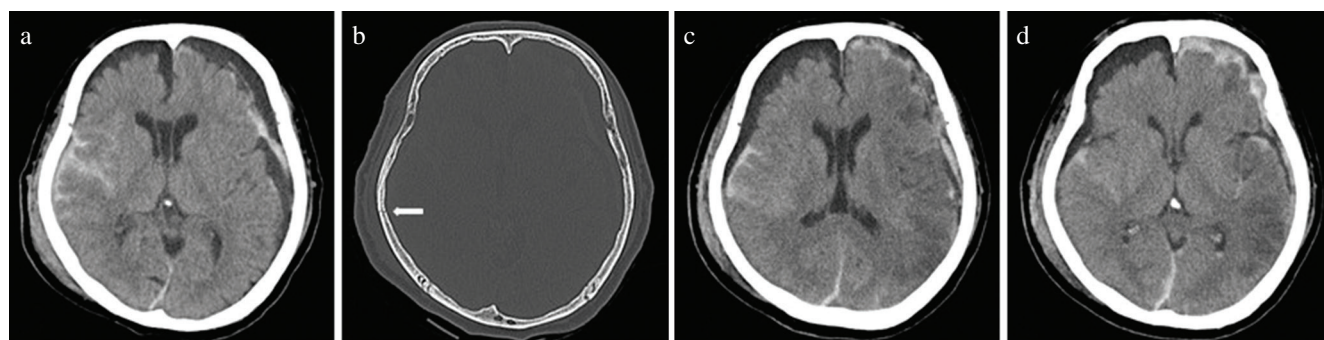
(a) Admission computed tomography (CT) scan showing diffuse traumatic subarachnoid hemorrhage of the whole cerebrum and a left subdural hematoma within a hygroma. (b) Bone-window CT scan shows a linear skull fracture (arrow) in the right temporoparietal region. (c and d) Five days after admission, plain CT showed multiple low-density areas in the left hemispheric cerebrum and slight brain edema with disappearance of the subdural hematoma.
